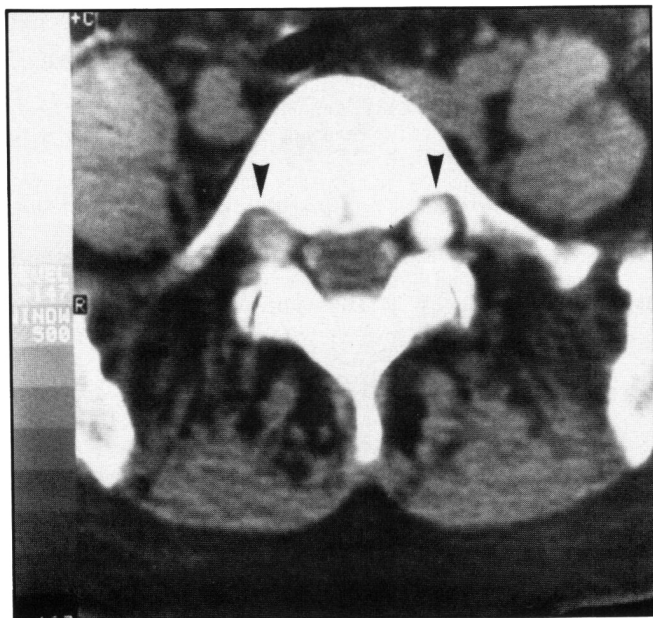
CT scan examination with intrathecal metrizamide shows widening of neural foramina by the cysts (arrows).
